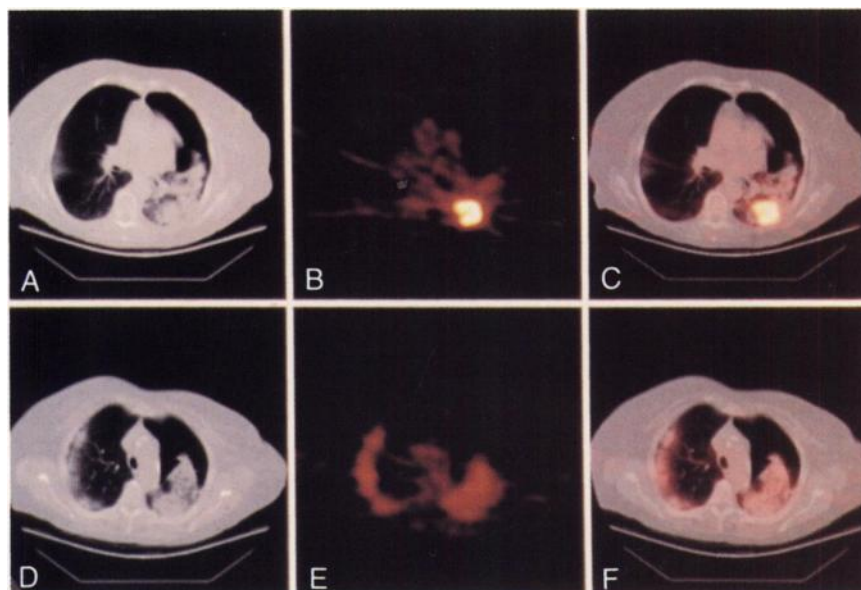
Two axial slices are shown. (A, D) CT scans, (B, E) PET scans and (C, F) merge images for the two slices, respectively.
